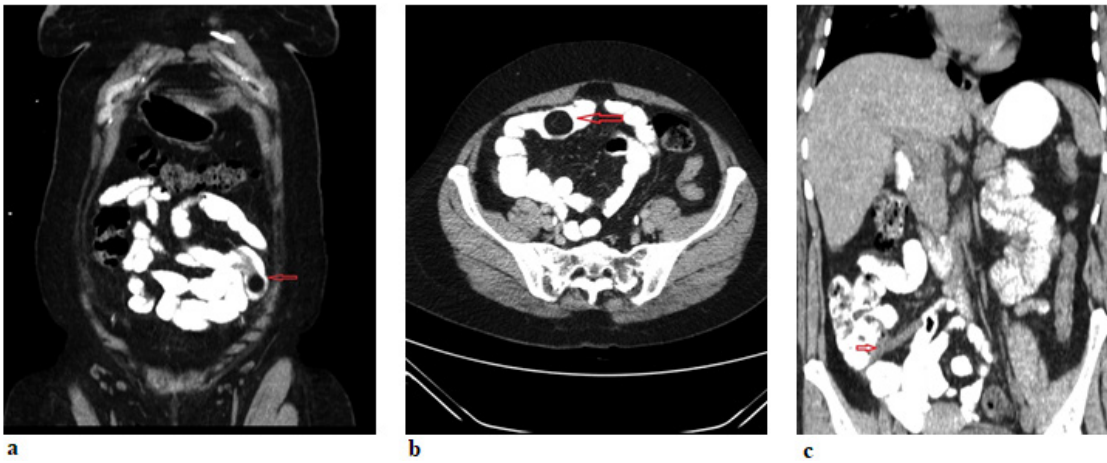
a) Coroner section of CT of the abdomen revealed 2 cm target-like mass, tumor with fat density and ileo-ileal intussusception. b) Axial section of CT of the abdomen that showed ileo-ileal intussusception. c) CT image of signs of appendicitis. (increasing on appendix diameter, edema)
